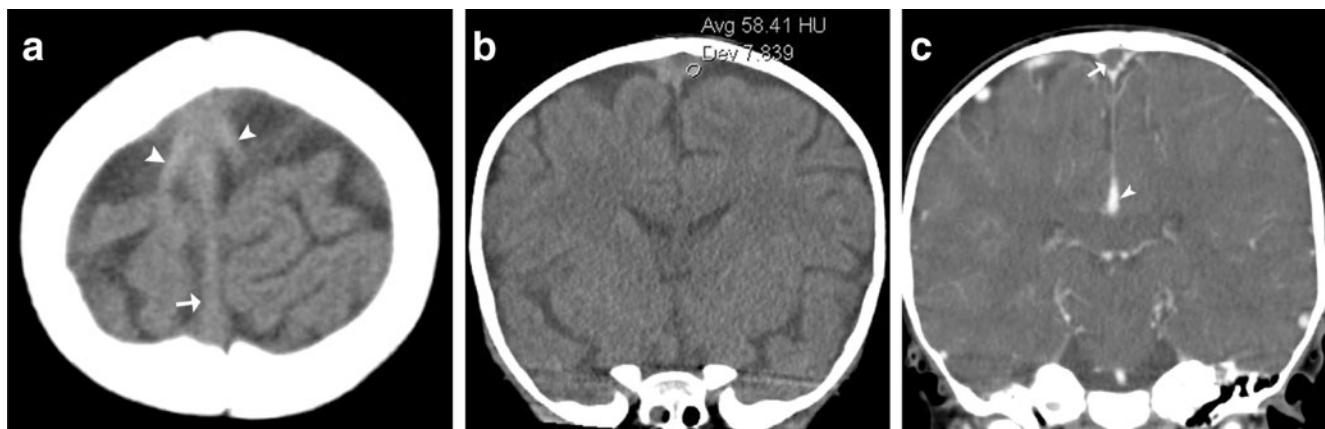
Iron deficiency anemia and sinovenous thrombosis in a 10-month-old girl with lethargy and new onset of generalized seizures. a Axial unenhanced CT image shows distention and increased attenuation of cortical dural veins (*arrowheads*). The superior sagittal sinus appears normal (*arrow*). b Coronal CT reformation shows a CT HU
